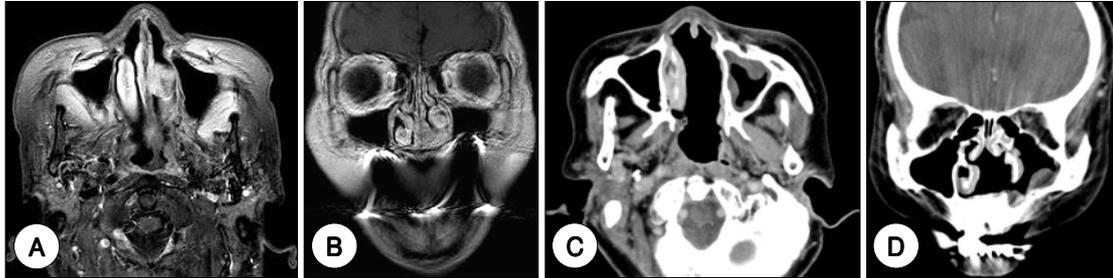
Images of case 3. Axial (A) and coronal (B) T1 enhanced images show well enhancing recurrent mass abutting nasal cavity floor and invading nasal septum after 32 months operation. There is no evidence of residual or recurrent tumor on axial (C) and coronal (D) CT images after 39 months post reoperation.
